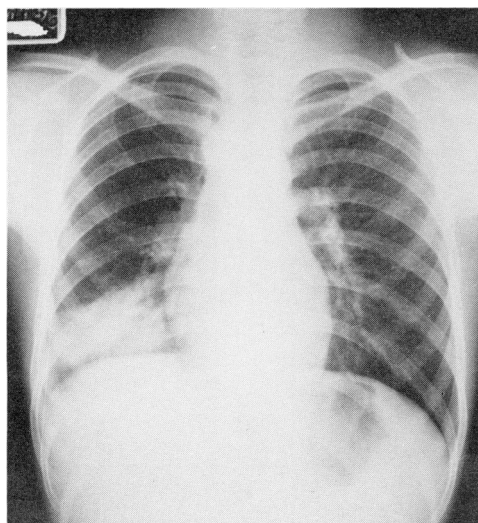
First chest X-ray film (Case 2).
